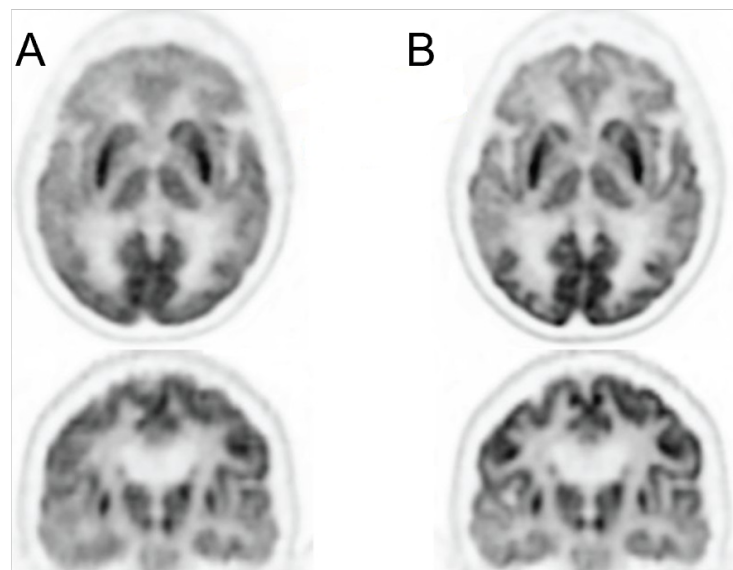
Axial (top) and coronal (bottom) slices of a ^{18}F -FDG PET study showing the reconstructed image without motion correction (A) and with rigid motion correction (B). Adapted from Spangler-Bickell et al. [141].
